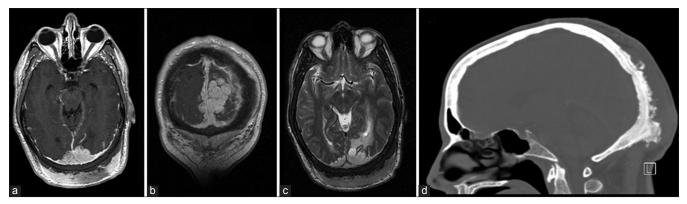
Axial (a) and coronal (b) contrast-enhanced TI-weighted MRI demonstrates tumor encasing the posterior portion of the superior sagittal sinus extending into the torcula. Abnormal thickening of the posterior scalp is seen. (c) Axial T2-weighted MRI sequence demonstrates abnormal hyperintensity in the white matter of the occipital lobe consistent with vasogenic edema from parenchymal tumor invasion. (d) Sagittal view of contrast-enhanced CT scan, bone window, shows that the occipital bone is both hyperostotic and thickened from tumor infiltration
